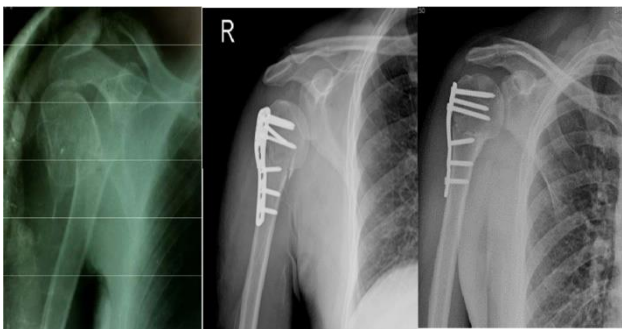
Pre and post-operative X-ray of a PHILOS plating case.
